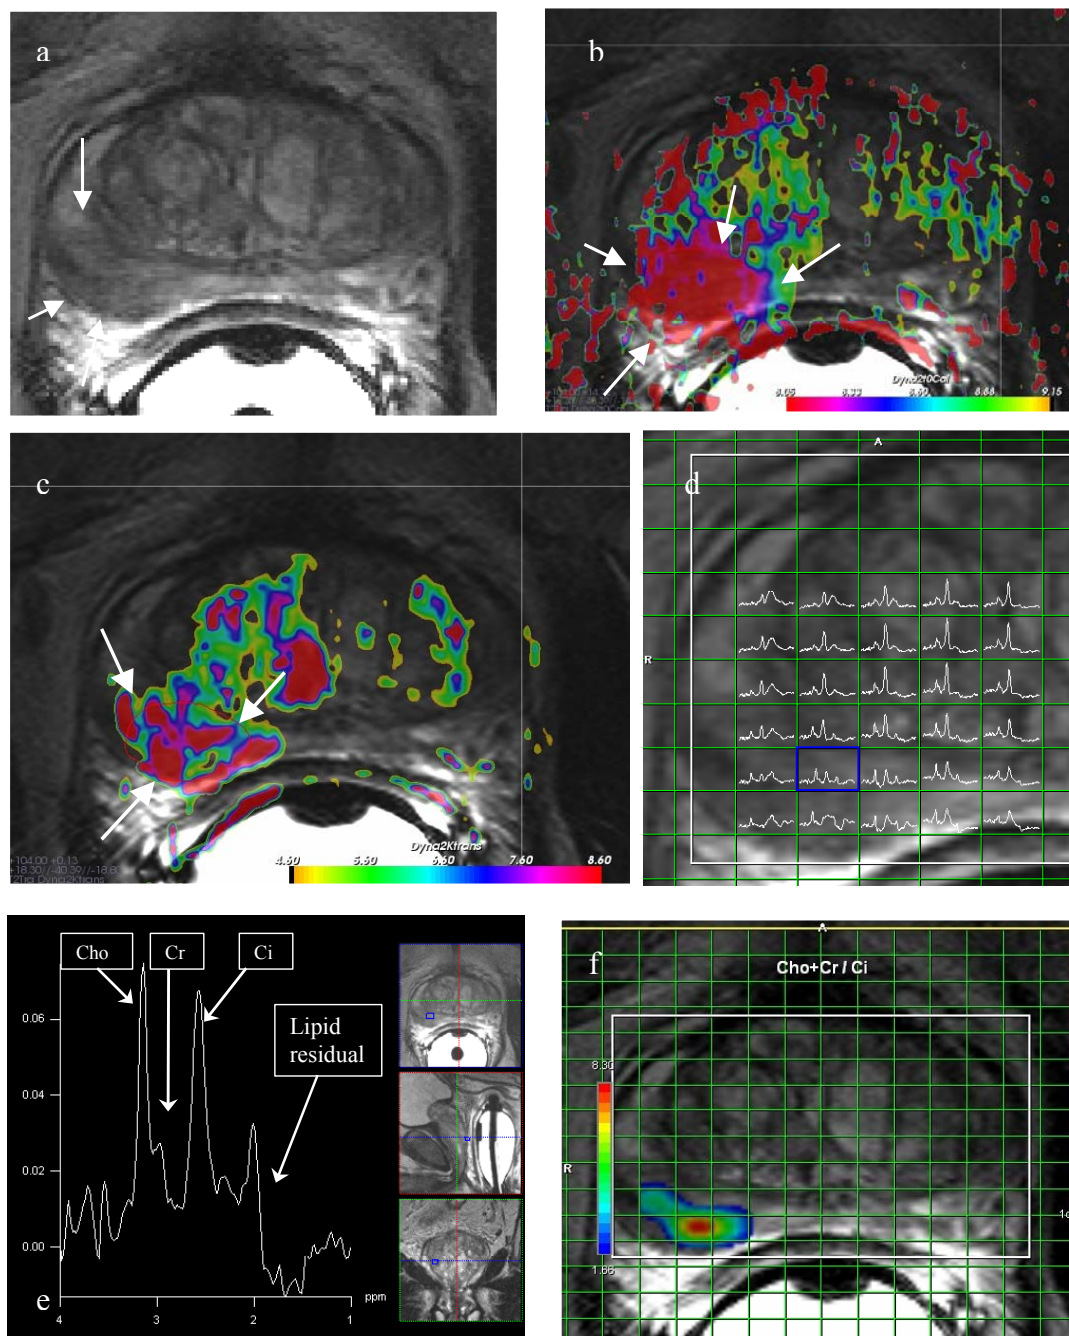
DCE-MRI and MRSI results of patient no. 4.
